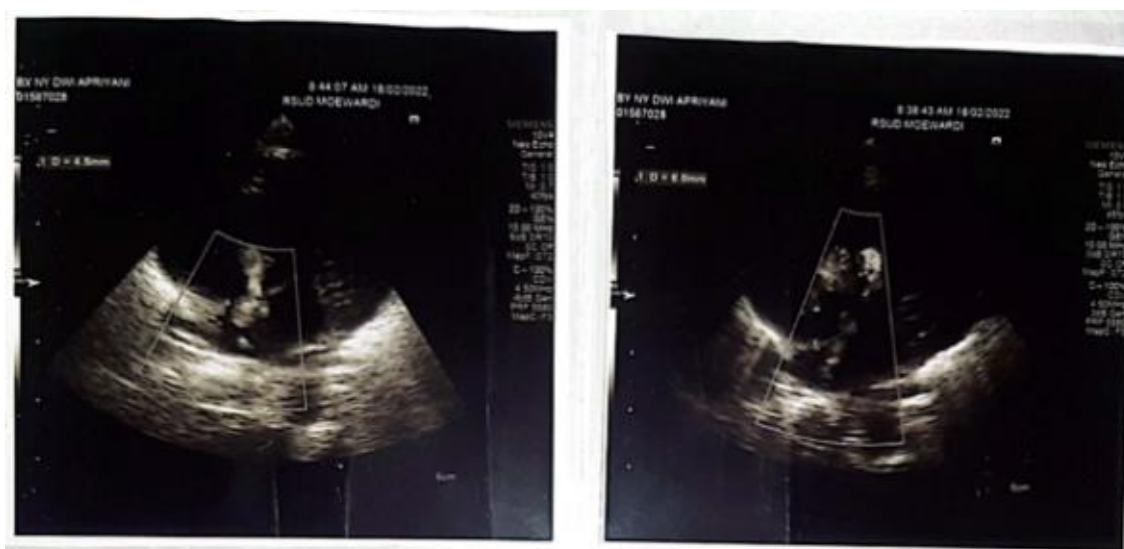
Echocardiography of a 1-day-old baby
